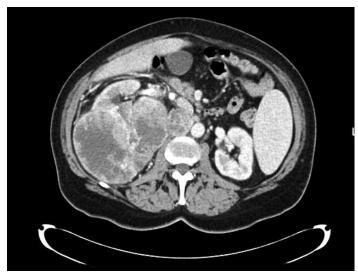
CT scan demonstrating a 12 cm, right renal mass with bulky regional lymphadenopathy. On final pathology this was found to be a T3N1M0 clear cell RCC with sarcomatoid transformation.
